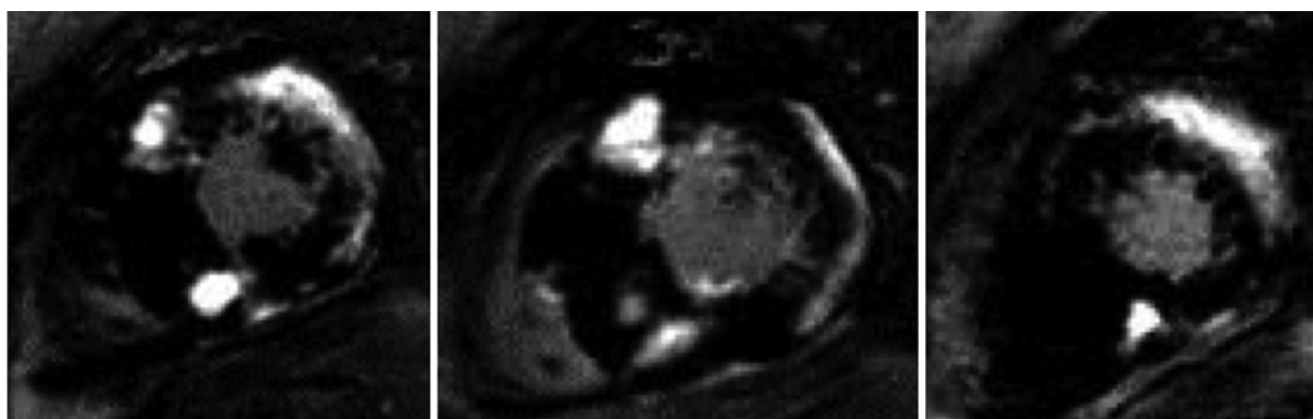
MRI with late gadolinium enhancement indicative of fibrosis in HCM
